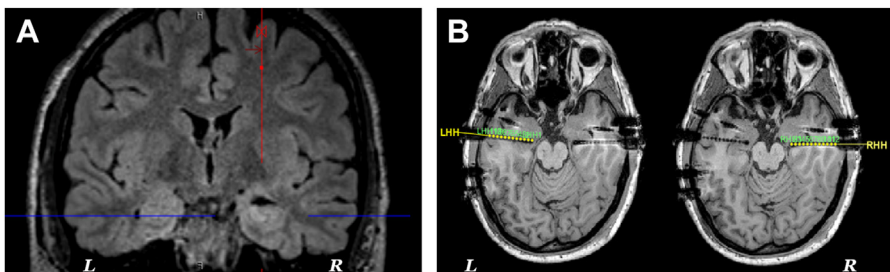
A patient with temporal lobe epilepsy who underwent bilateral temporal sEEG to establish laterality of seizure origin. (A) Coronal FLAIR section showing hyperintensity in the right hippocampal region. (B) sEEG electrode reconstruction over a postoperative T1. The left (LHH) and right (RHH) sEEG electrodes implanted in an orthogonal fashion from the middle temporal gyrus targeting the respective hippocampi in the anterior/head region (LHH: left hippocampus head; RHH: right hippocampus head). This intracranial investigation confirmed the potential of the right hippocampus to generate the typical seizures of the patient, and showed no ictal involvement of the left hippocampus. The iEEG samples shown in the following Figs. 3–6 are derived from this sEEG investigation.
